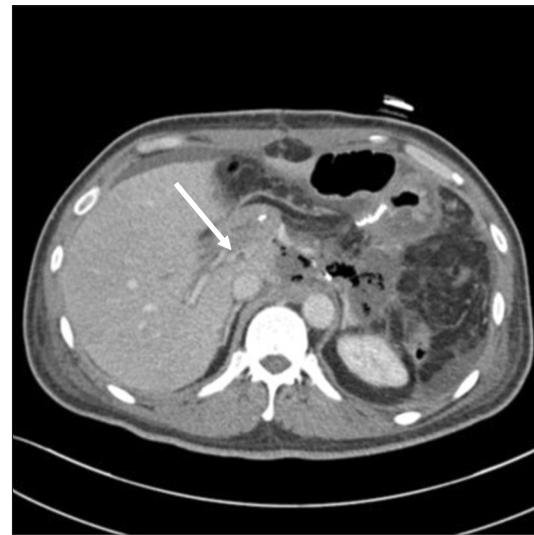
Computed tomography performed two weeks after total pancreatectomy showed thrombosis (arrow) in the extrahepatic portal vein.
